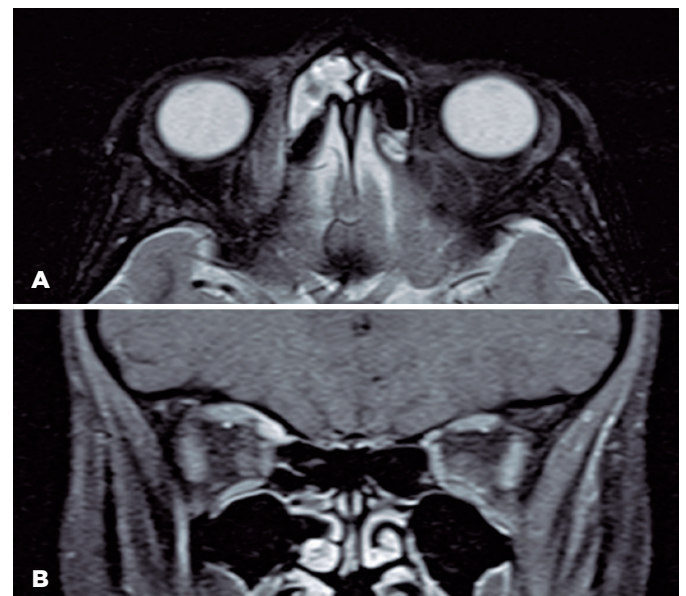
MRI of the orbits. A) Axial T2 without contrast and fusiform enlargement involving the whole right superior oblique muscle. B) Coronal T1 image with contrast showing the enlargement of the right superior oblique muscle with enhancements of the gadolinium contrast.
